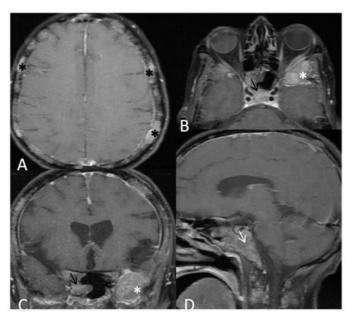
(A, B, C & D) Post-contrast T1WI axial, coronal and sagittal images from MRI brain showing well-defined, intensely enhancing masses in the calvarium (black asterisk), greater wing of left sphenoid with extra-dural and extra-conal components (white asterisk) and right lateral wall of the sphenoid sinus (black arrows), and clivus (white arrow).
